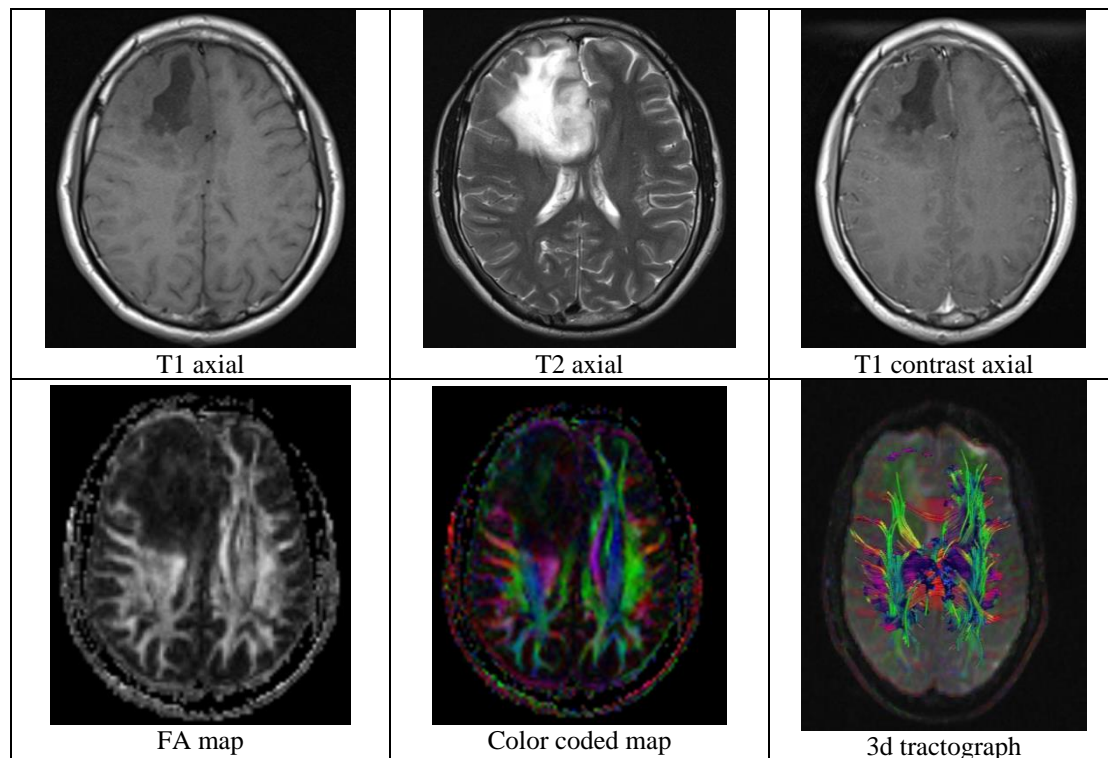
A twenty three old male patient with WHO grade IV glioblastoma multiforme: MRI shows a large T1 hypointense T2 hyperintense lesion, post contrast showing central non enhancing necrotic area. DTI shows disruption of superior, inferior occipitofrontal fasciculus, corticospinal tract.
